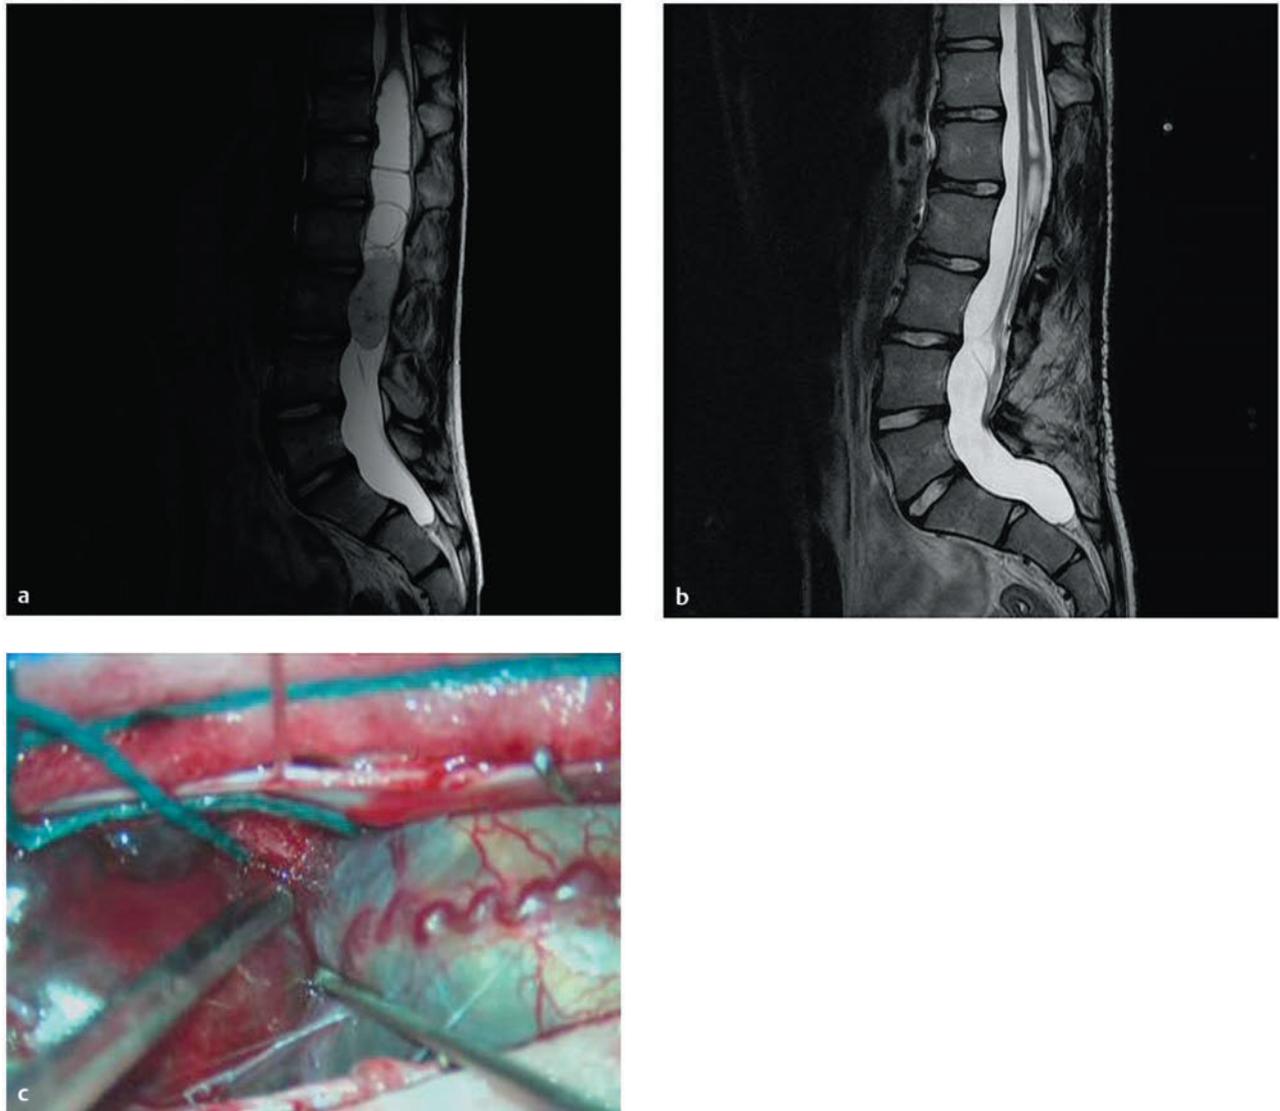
A 14-year-old boy presented with progressive back pain. (a) T2-weighted magnetic resonance image shows a solid mass at the tip of the conus/proximal cauda equina. (b) Image after decompression and gross total resection of a myxopapillary ependymoma. (c) Intraoperative photograph.
